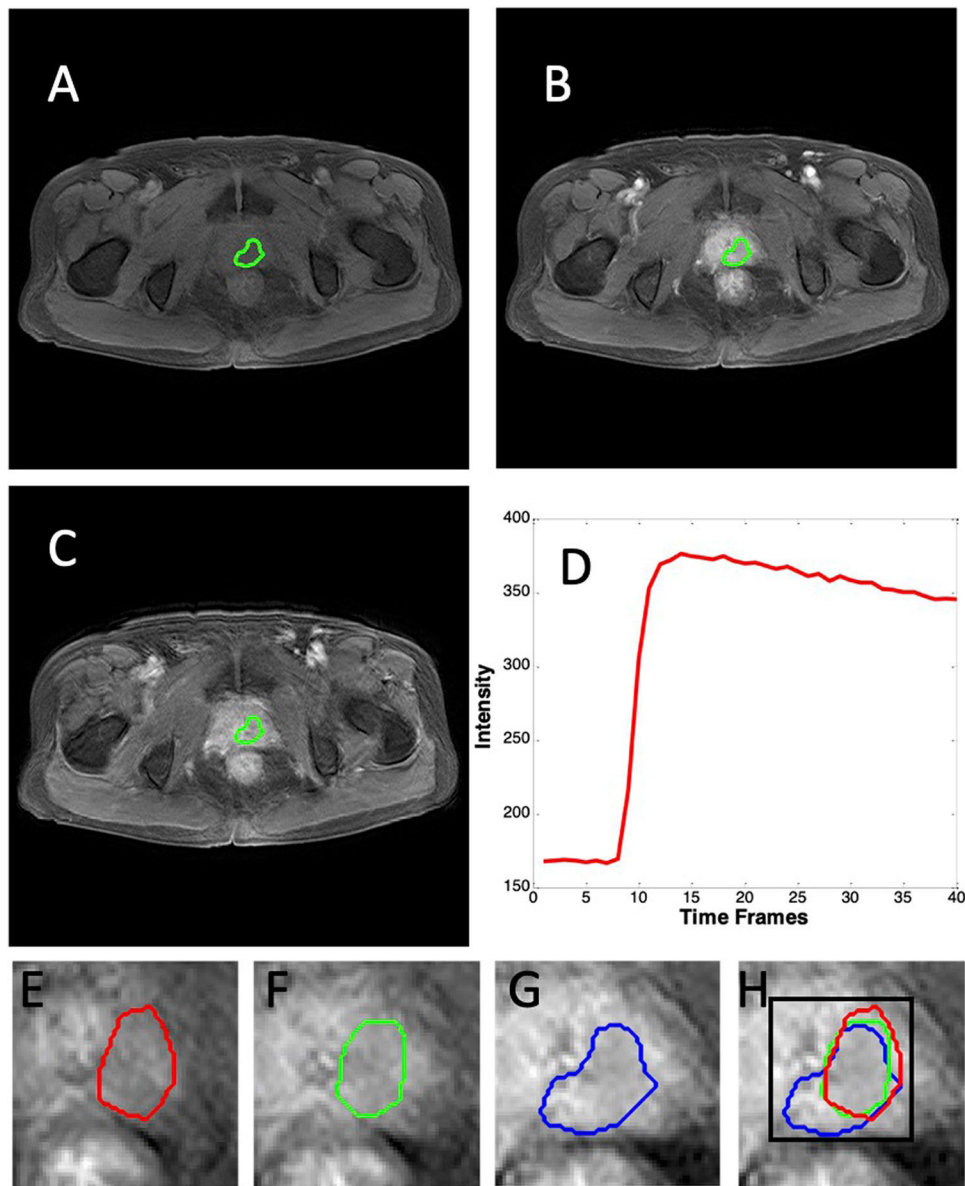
A case example of an 83-year-old man with prostate cancer (tPSA = 7.13 ng/mL, Gleason Score = 4 + 5). The suspicious lesion is manually outlined. A The first DCE-MRI time frame (pre-contrast image); B the 15th time frame post-contrast image; C the 40th time frame post-contrast image; D the DCE-MRI time-intensity curve shows the washout pattern. E, F, G The tumor ROIs drawn on 3 consecutive slices; H the projection of 3 tumor ROIs, and the square smallest bounding box to cover the outer boundary
